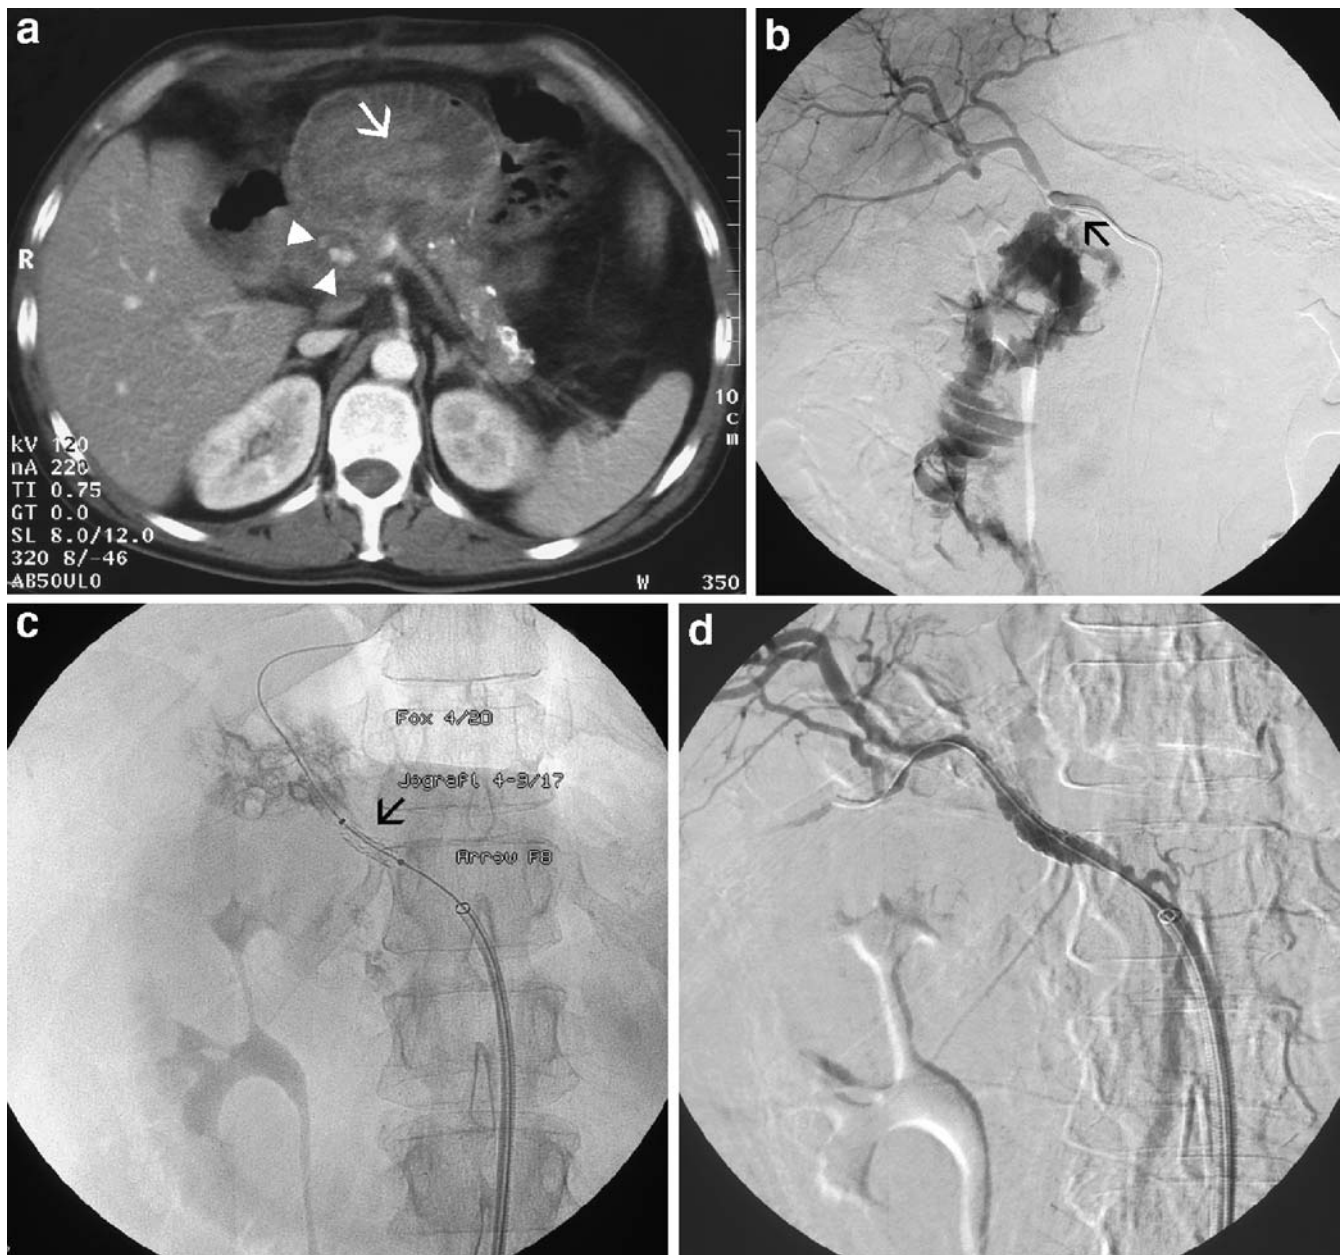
A 50-year-old patient with suspected bleeding 18 days after duodenum-preserving pancreatic head resection. a: Contrast-enhanced CT of the upper abdomen demonstrates changes of chronic pancreatitis with foci of calcification in the pancreatic body and tail. Anterior to the pancreas there is a dilated loop of small bowel, filled with material of high attenuation (arrow), which was also seen on the non-enhanced scan (not shown), compatible with coagulated blood. In the anatomic area of the resected pancreatic head, contrast enhancing “spots” (arrowheads) are evident. b: Selective angiography of the common hepatic artery demonstrates massive contrast
